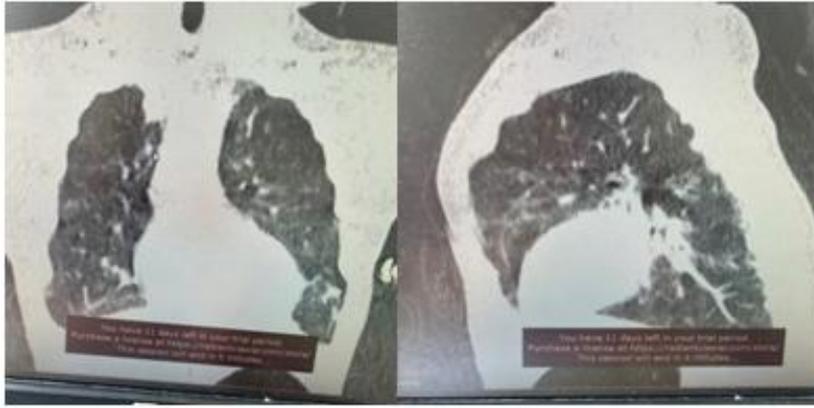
Chest CT - residual adhesions and areas of air trapping and atelectasis, as a consequence of the underlying condition
